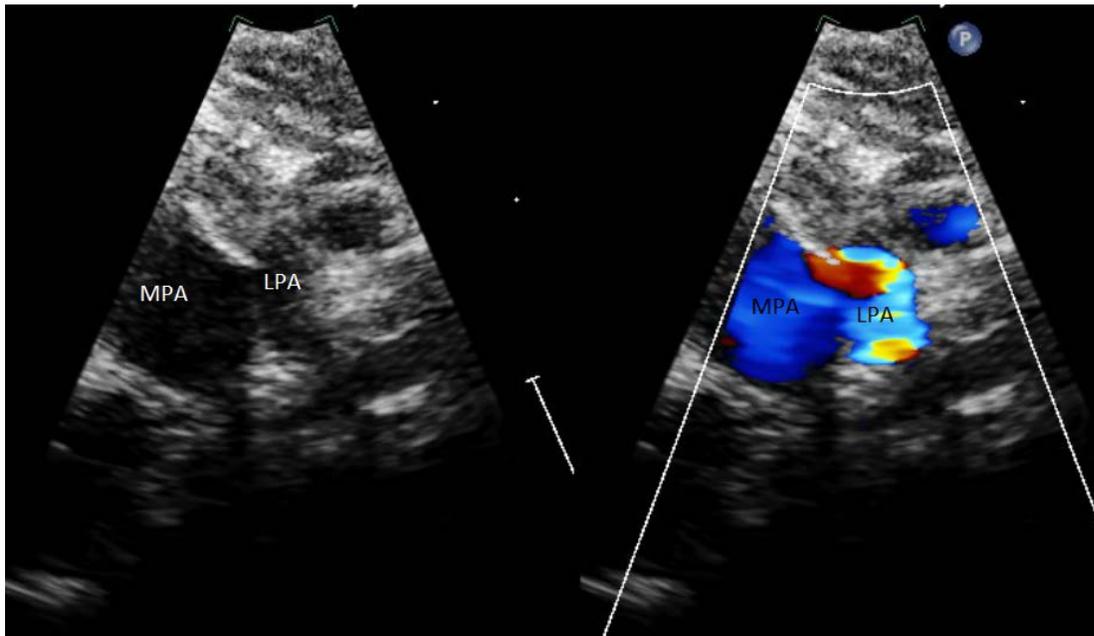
Parasternal short axis color flow echocardiogram performed after intervention showing reimplantation of the left pulmonary artery to the main pulmonary artery. MPA-Main Pulmonary Artery, LPA-Left Pulmonary Artery
